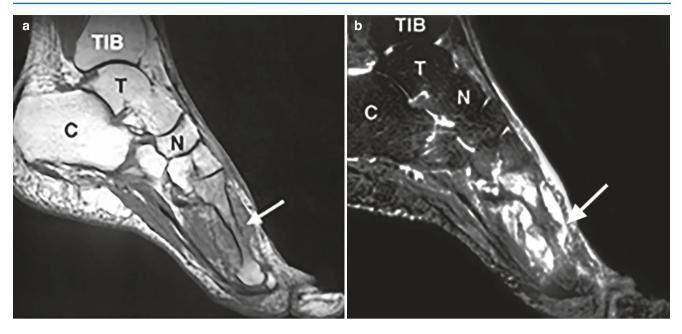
Stress fracture on MRI. Sagittal T1-weighted (a) and STIR (b) MR images of the foot demonstrate cortical irregularity of the middiaphysis of the metatarsal bone (arrow). The marrow signal is abnormal, consistent with a marrow edema pattern: low signal on the T1-weighted image and high signal on the fluid-sensitive STIR image.
